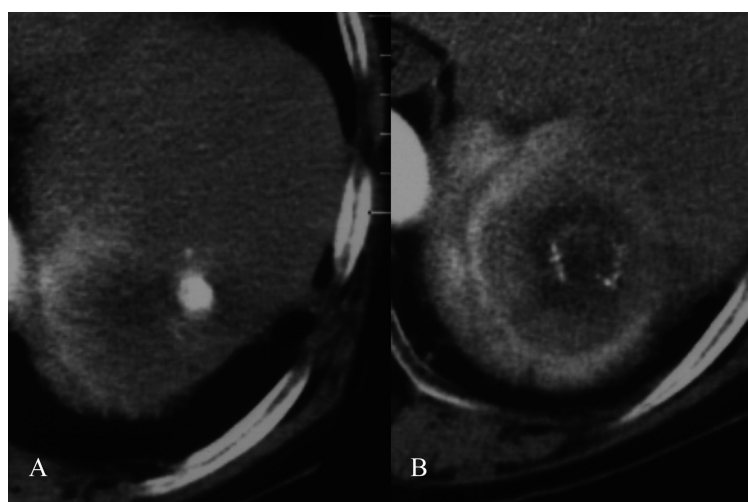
A, Contrast-enhanced computed tomography performed 5 months after TACE and splenic chemo-infusion. Hepatic tumor has completely accumulated iodized oil without enhancement. B, Splenic tumor has grown to 5 cm in diameter, with slight enhancement and partial accumulation of iodized oil. Slice B is 2 cm caudal side of slice A.
